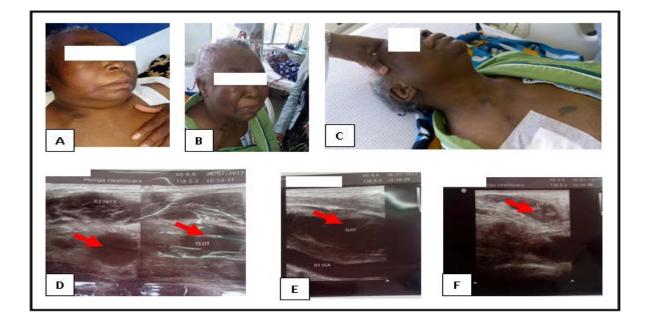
A- A.N face at presentation, B-C: -A.N three weeks after initiation of treatment. D-F- Doppler ultrasound depicting thrombi (red arrows).
